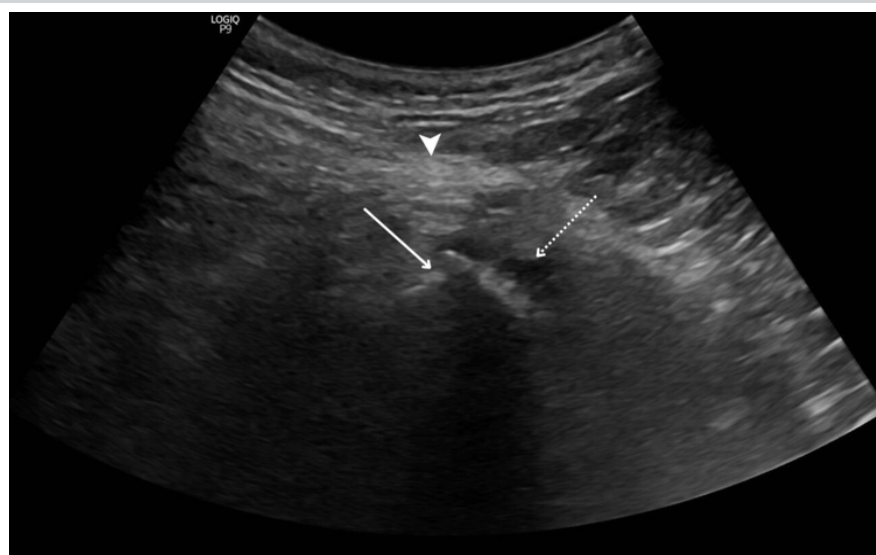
Ultrasonography of the proximal right thigh shows a hyperechoic focus (solid arrow) with posterior acoustic shadowing along the linea aspera with adjacent cortical irregularities. Minimal surrounding free fluid (dashed arrow) noted. The muscles appear hyperechoic, suggestive of inflammatory changes (arrow head).
